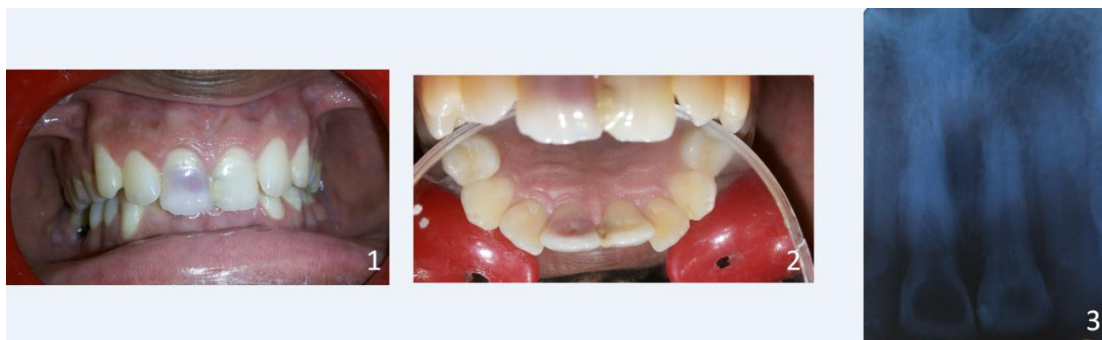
Preoperative facial view; 2. Preoperative palatal view; 3. Preoperative radiograph
